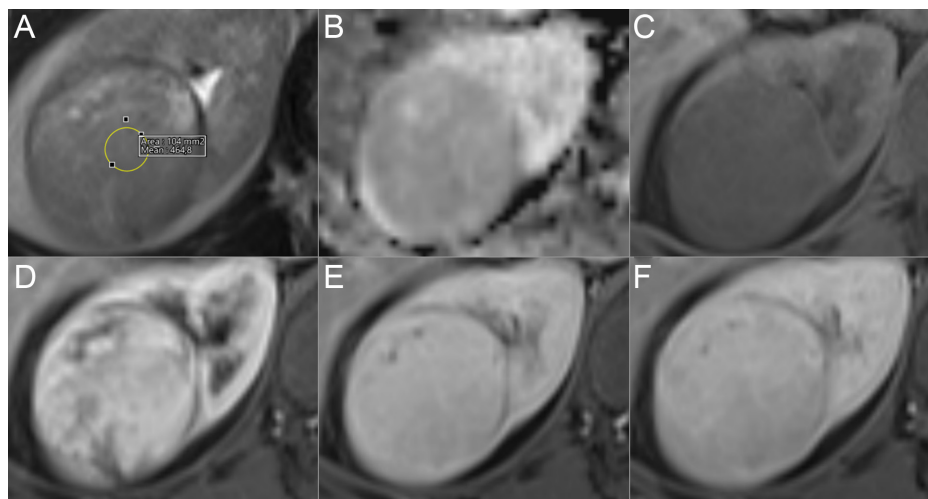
Oncocytoma in the right kidney of a 41-year-old man. (A) Axial T2-weighted magnetic resonance image shows a renal mass with slightly high SI compared to renal parenchyma (T2SIR = 116). (B) Apparent diffusion coefficient (ADC) maps show diffusion restriction in the renal mass (ADCr = 75). Axial non-enhanced (C) and contrast-enhanced T1-weighted MR images in corticomedullary (D), nephrogenic (E), and delayed (F) phases show strong heterogeneous enhancement of mass in corticomedullary followed by washout (ERc: 281.9, ERn: 259, ERd: 250.4). ADCr, ADC ratio; ERc, corticomedullary phase enhancement ratio; ERd, delayed phase enhancement ratio; ERn, nephrogenic phase enhancement ratio.
